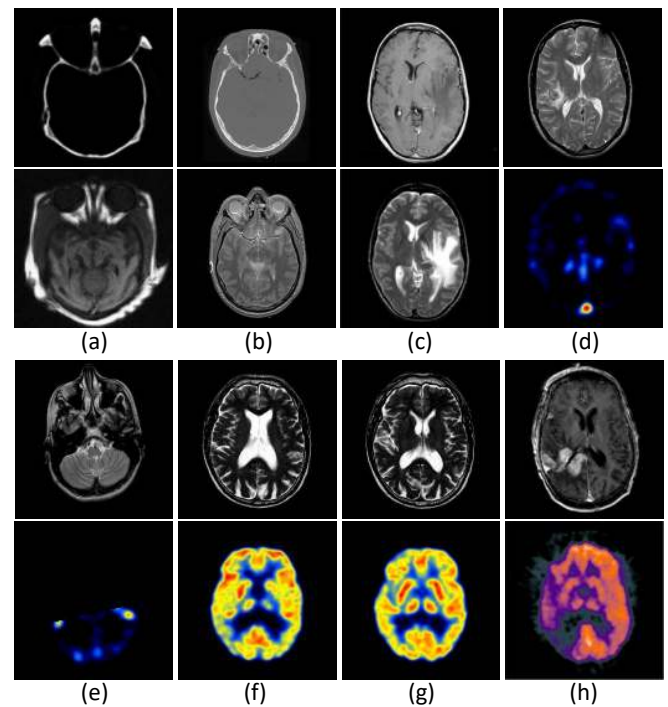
Source images for experiments. (a), (b), (c) are CT-MRI image pairs; (d), (e) are MRI-SPECT image pairs; (f), (g), (h) are MRI-PET image pairs.
